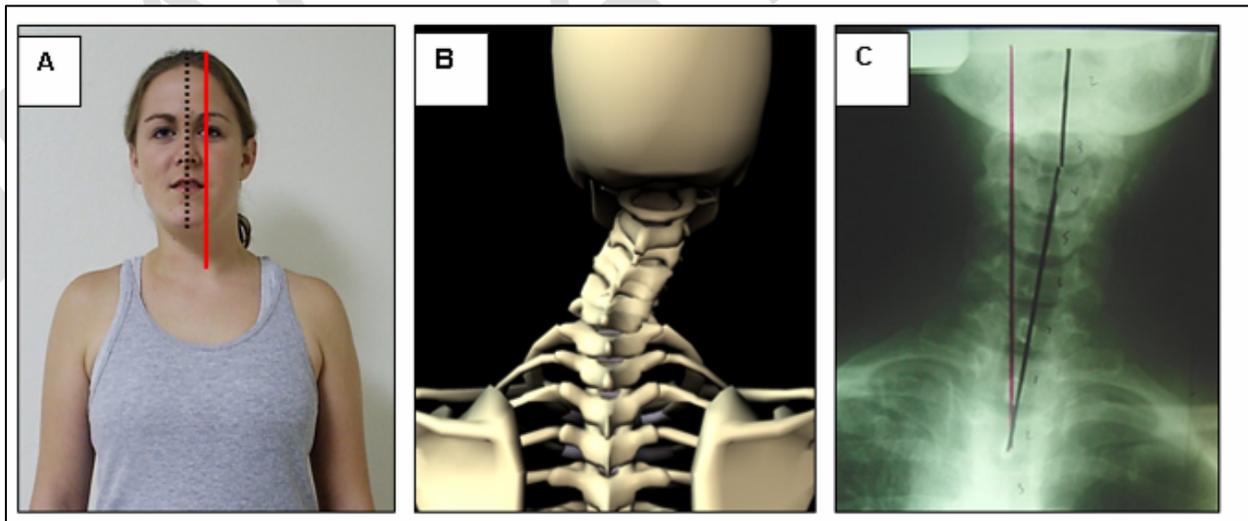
Postural Main Motion and Coupled motion. In A, the posture of right head translation is shown. In B, the skeletal animation from the posterior to anterior view is shown depicting the opposite lateral bending coupling motions in the mid-low cervical spine versus the mid-upper cervical spine. In C, a patient radiograph is shown with the coupling patterns for right head translation. Reprinted with permission from Harrison CBP Seminars Inc., Evanston, WY.
